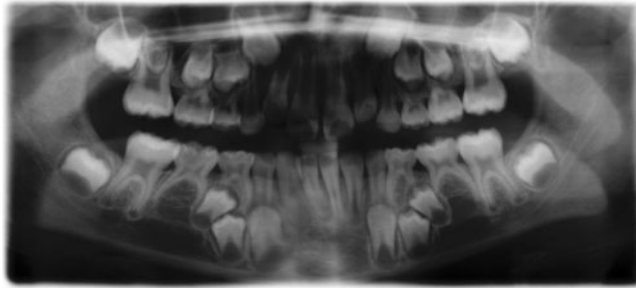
Panoramic radiograph (20-04-99)
